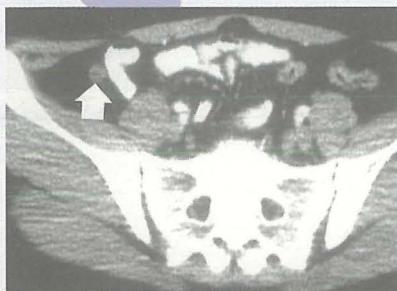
CT scan showing a normal appendix in cross-section (arrow).
